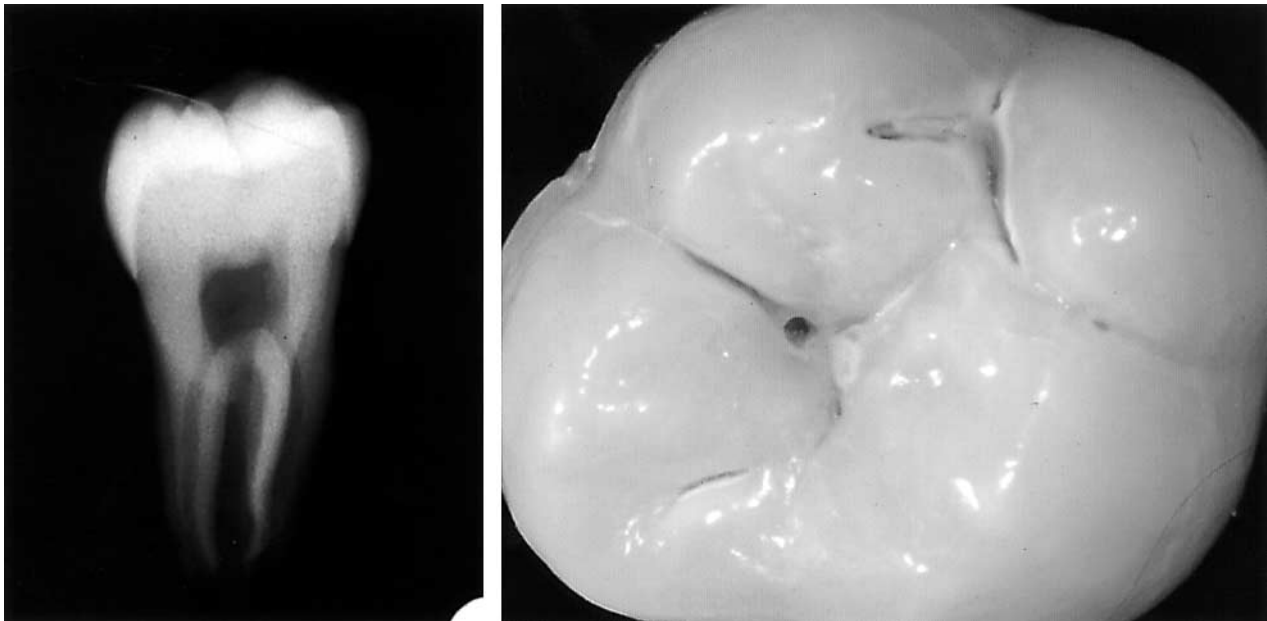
Tooth A – clinical and radiographic appearance of a second molar.
